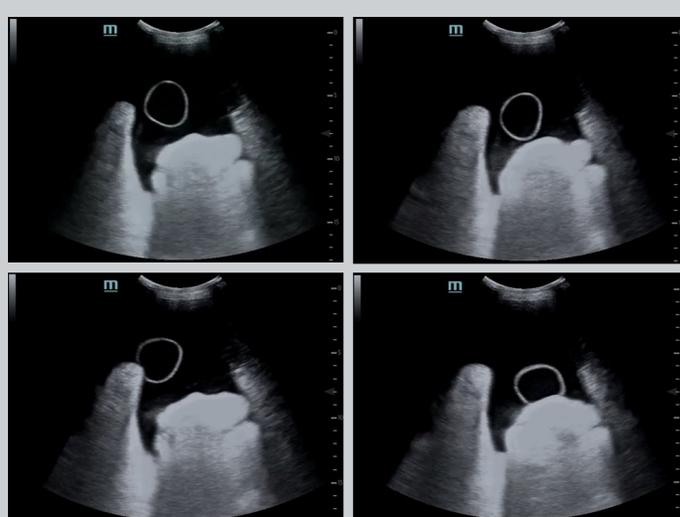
Point of Care Ultrasound of Right Lower Abdominal Quadrant. Four still images captured from the 6 seconds of video recording.
